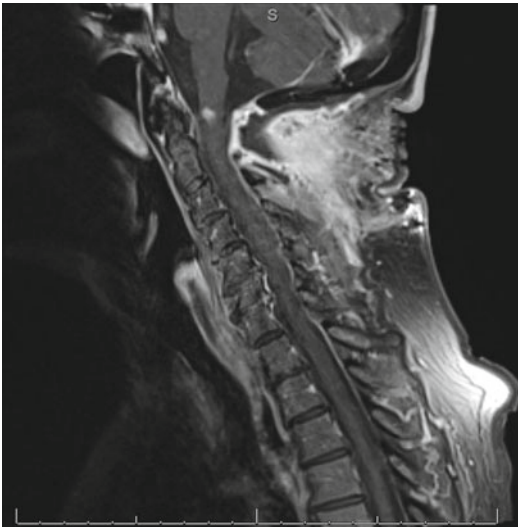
T1-weighted MRI with contrast enhancement showing a cavernous malformation
